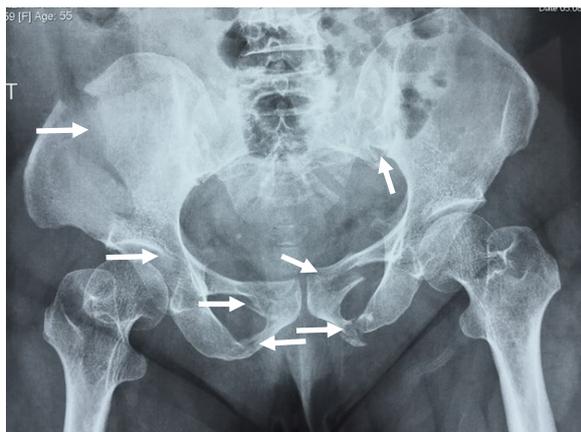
Pre-operative radiograph (White solid arrows indicating points of fracture of the pelvis)
